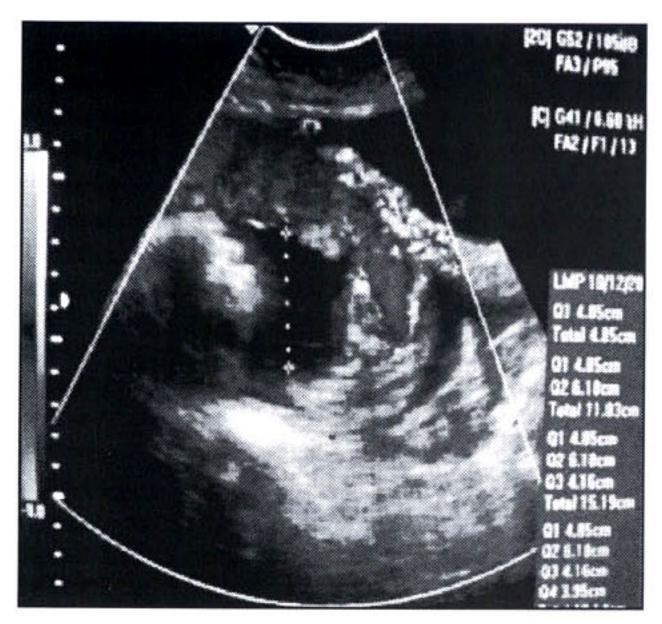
Color doppler of placenta and bladder invasion longitudinal.
